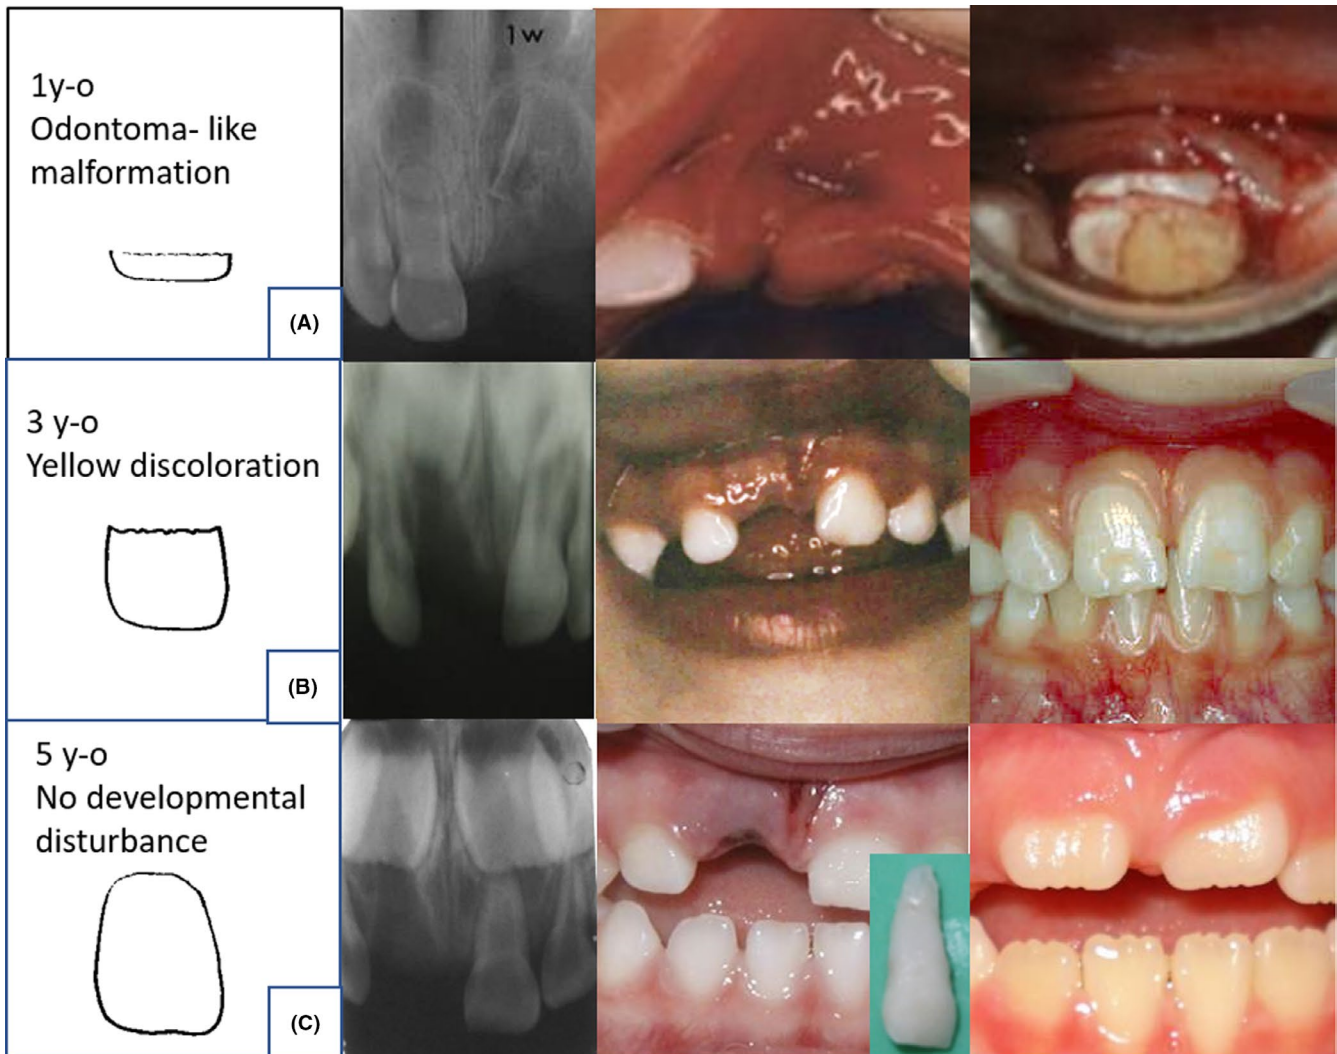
Long-term sequelae after avulsion of primary incisors and age at the time of injury. A, Severe injury to the developing permanent incisor. Avulsion of the primary maxillary left central incisor in a 10-month-old boy. The radiograph shows the permanent maxillary left central incisor displaced and initial calcification of the crown. An odontomalike malformation developed, which means a loss of the permanent tooth. B, Avulsion of the primary maxillary right central incisor at the age of 3 y. The child swallowed the avulsed tooth. While the mother was changing diapers the day after, she found the tooth in the excretion. A yellow discoloration is seen in the permanent maxillary central incisors (a mild disturbance to the developing teeth). C, Avulsion of the primary maxillary right central incisor at the age of 5 y. No sequelae have affected the crown of the permanent maxillary right central incisor
